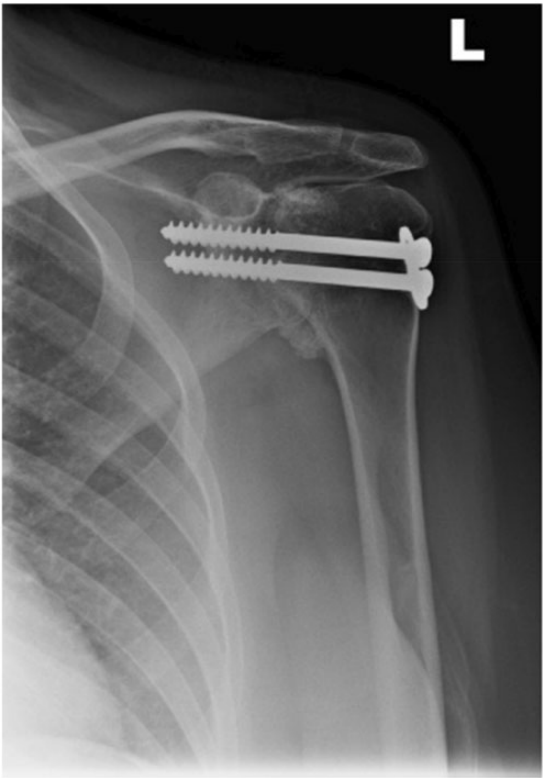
Anteroposterior radiograph of a 31-year-old right hand-dominant female, 7 months after left glenohumeral arthrodesis using two transhumeral lag screws.
